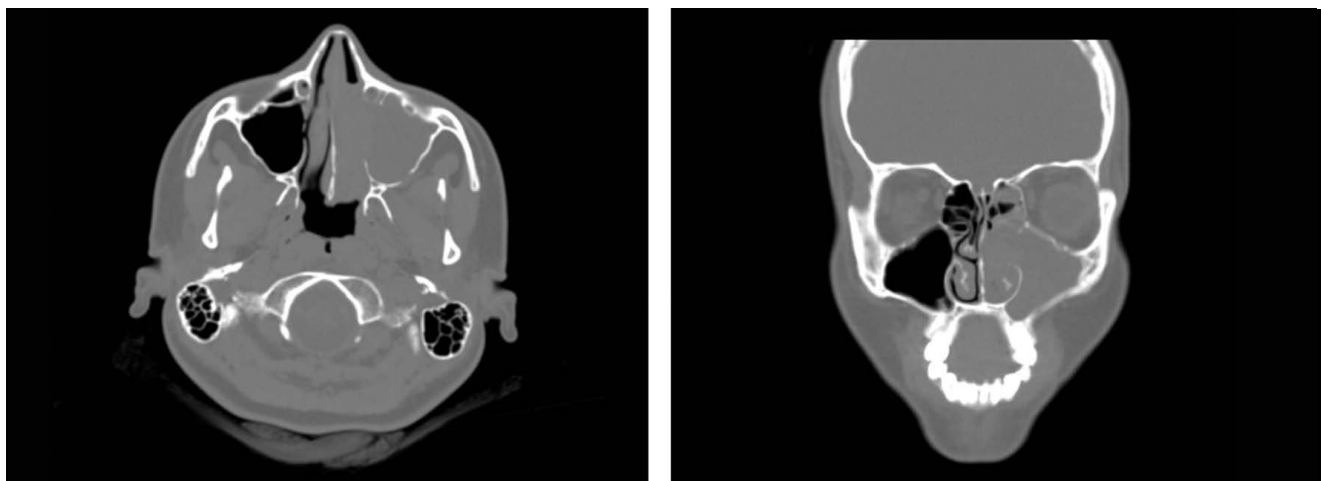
Computed tomography - maxillary sinus, frontal sinus and ethmoidal tumor.
